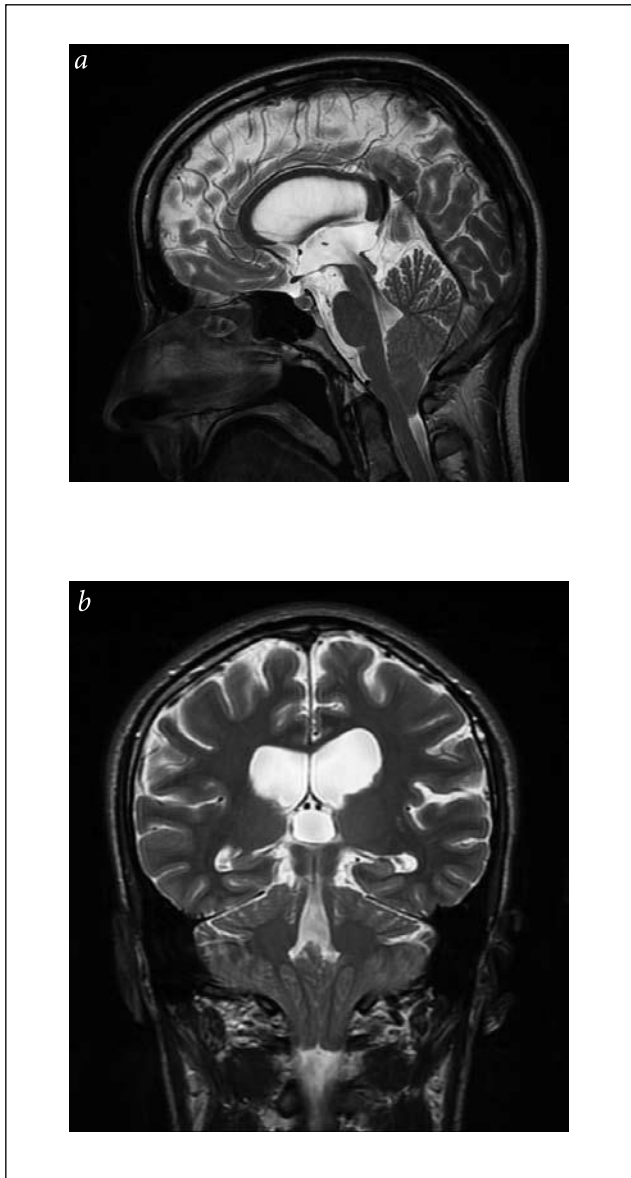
An 11-year-old boy with headaches, without neurological signs and symptoms. MRI study, FSE/T2-weighted images. Tonsillar ectopia with depth of 11 mm is seen in the sagittal plane (a). Non-active supratentorial ventriculomegaly is observed in the coronal projection (b).
